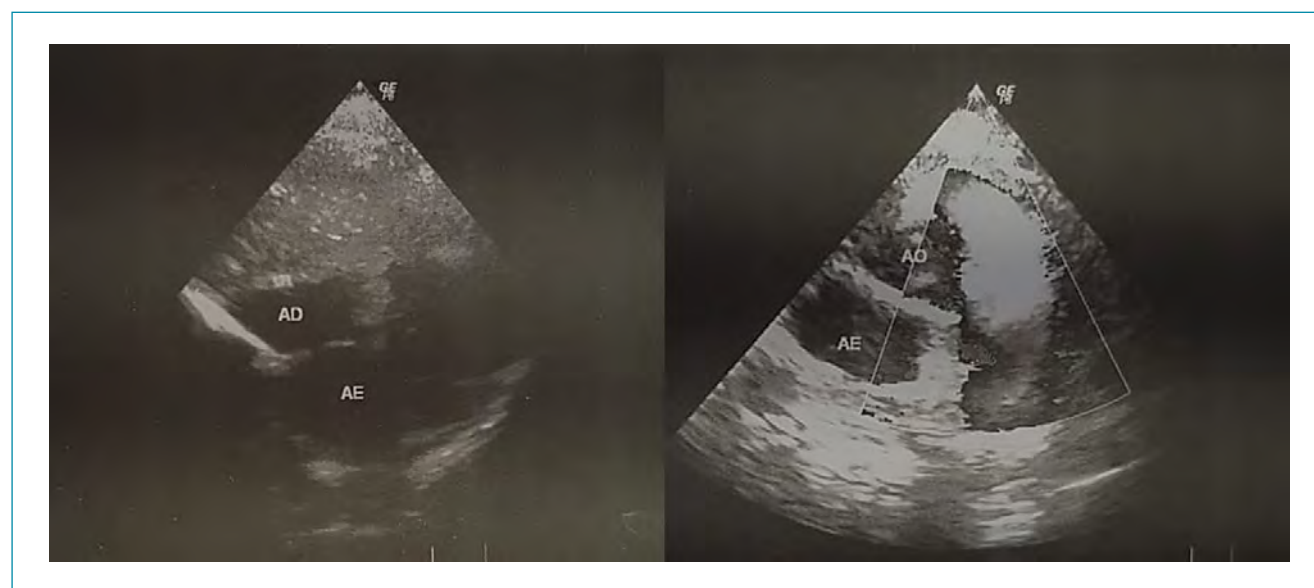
Transthoracic echocardiography. No cardiac morphology and function abnormalities were found previously to the cardiac arrest.
